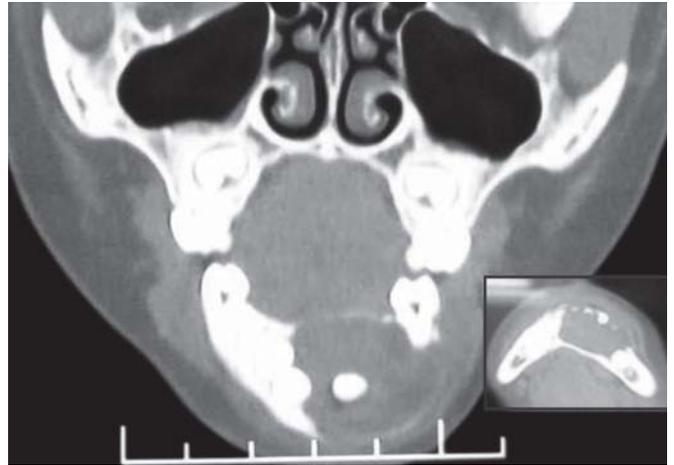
CT scan (coronal view)
